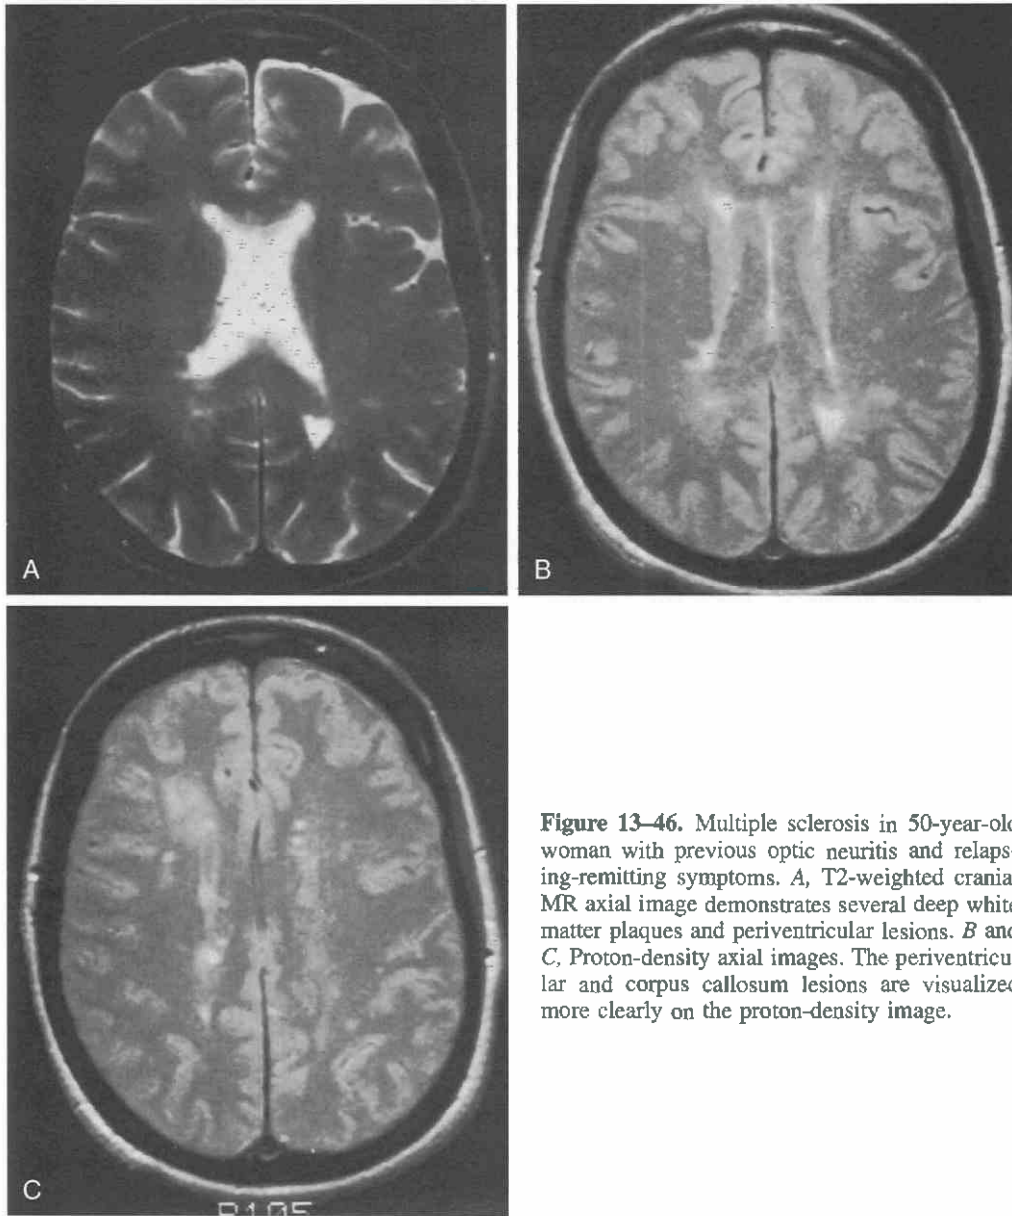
Multiple sclerosis in 50-year-old woman with previous optic neuritis and relapsing-remitting symptoms. *A*, T2-weighted cranial MR axial image demonstrates several deep white matter plaques and periventricular lesions. *B* and *C*, Proton-density axial images. The periventricular and corpus callosum lesions are visualized more clearly on the proton-density image.
